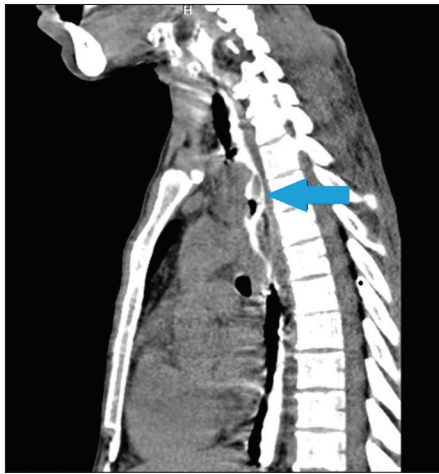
Sagittal contrast (oral) multi-detector computed tomography scan image of thorax showing irregular filling of the upper thoracic esophagus secondary to irregular wall thickening (arrow)
